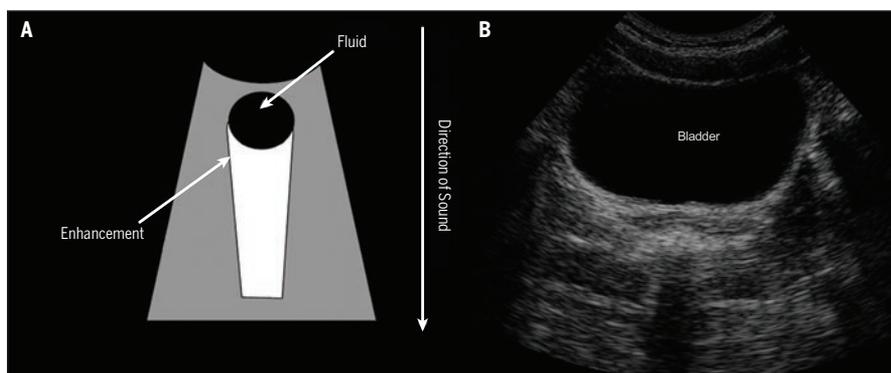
(A) Depiction of the enhancement of a region deep to a fluid-filled structure. Enhancement occurs as there is less attenuation of the propagating sound wave as it travels through a fluid-filled structure. (B) A transverse ultrasound image demonstrating enhancement of the midline pelvic floor structures deep to the bladder. Reproduced with permission Whittaker 2007.¹⁴²
